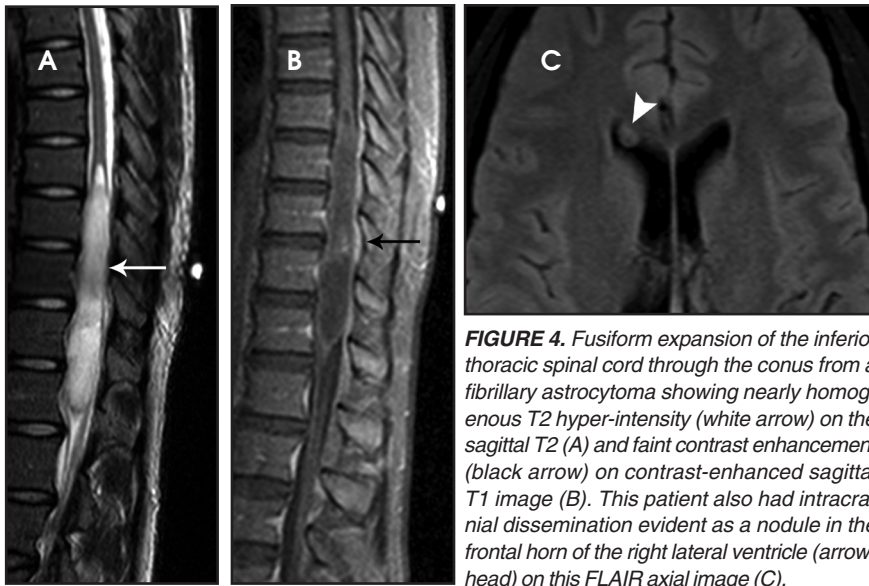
Fusiform expansion of the inferior thoracic spinal cord through the conus from a fibrillary astrocytoma showing nearly homogeneous T2 hyper-intensity (white arrow) on the sagittal T2 (A) and faint contrast enhancement (black arrow) on contrast-enhanced sagittal T1 image (B). This patient also had intracranial dissemination evident as a nodule in the frontal horn of the right lateral ventricle (arrow-head) on this FLAIR axial image (C).
